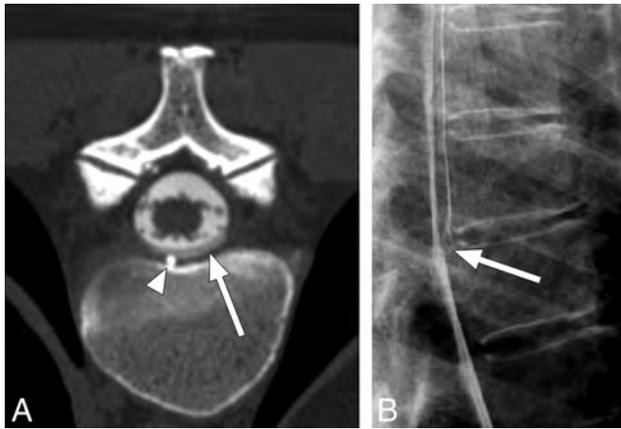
A 55-year-old woman with spontaneous intracranial hypotension secondary to a CSF leak. *A*, Postmyelogram CT at the level of the T7–8 disc interspace demonstrates a ventral CSF leak (*white arrow*) containing contrast with an attenuation slightly less than that of intrathecal contrast. A small spiculated osteophyte (*white arrowhead*) is the presumed cause for the leak. *B*, Lateral projection dynamic myelogram of the midthoracic spine confirms the origin of the CSF leak at T7–8. Note the split of the contrast column at this level consistent with a ventral CSF leak (*white arrow*).
